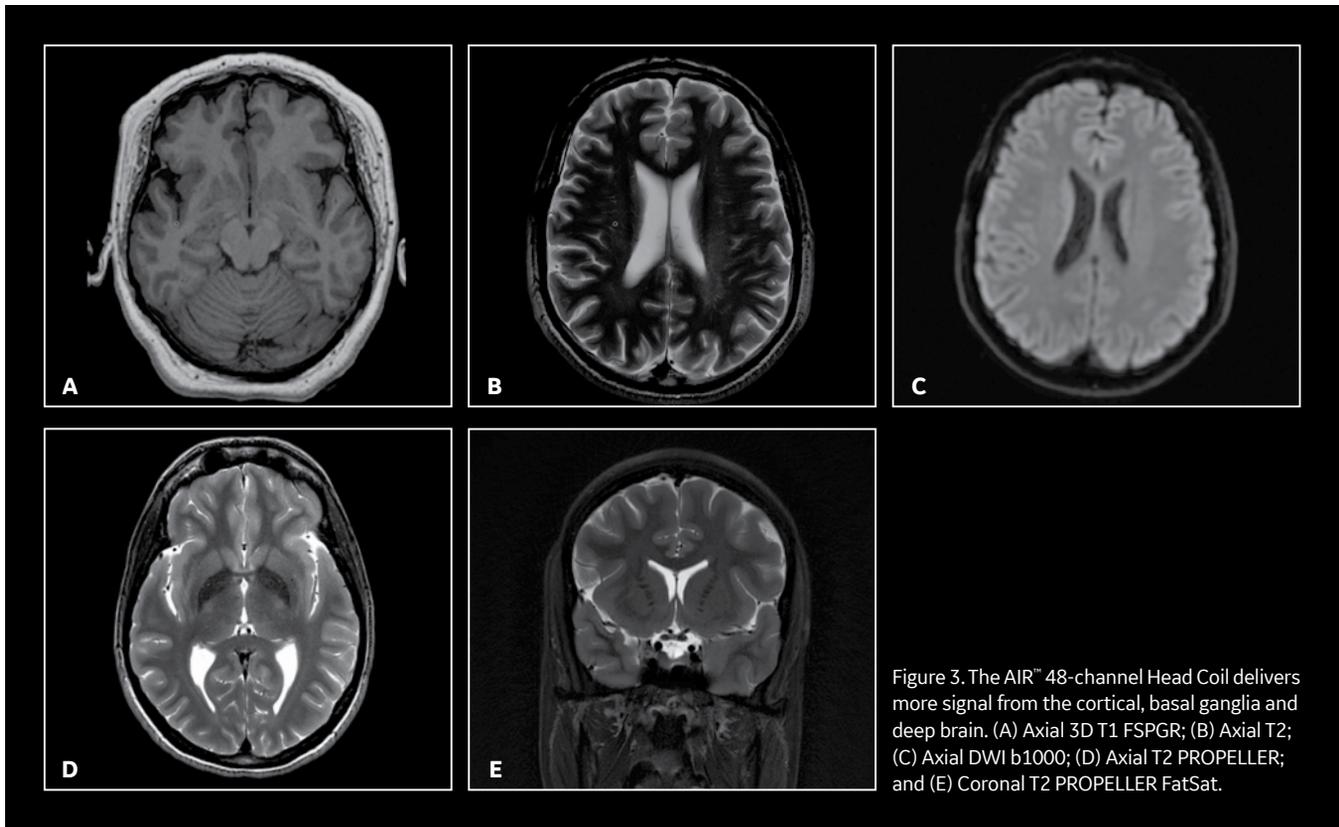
The AIR™ 48-channel Head Coil delivers more signal from the cortical, basal ganglia and deep brain. (A) Axial 3D T1 FSPGR; (B) Axial T2; (C) Axial DWI b1000; (D) Axial T2 PROPELLER; and (E) Coronal T2 PROPELLER FatSat.
